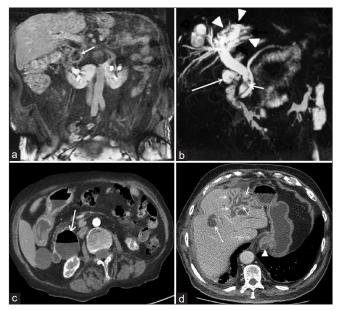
CT and MRI findings of LS. (a) MRI in coronal view shows PAD (arrow). (b) MRI-cholangiography shows left hepatic bile ducts dilatation (arrows head). PAD (long arrow). choledochus lithiasis (short arrow). (c) The CT in axial view shows a rounded image with an air/fluid level corresponding to the PAD (arrow). (d) CT in axial view shows left bile ducts dilation (short arrows). Biliary cyst (long arrow). CT: Computed tomography, MRI: Magnetic resonance imaging, LS: Lemmel's syndrome, PAD: Paravaterian diverticulum
